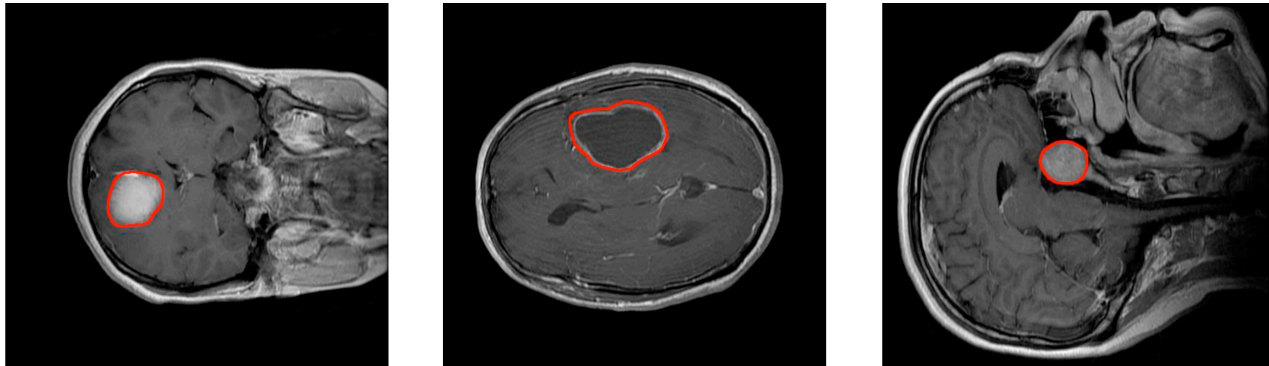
T1-CE MRI image dataset. Left: coronal view of a meningioma tumor. Centre: Axial view of a glioma tumor. Right: sagittal view of a pituitary tumor. Tumor borders have been highlighted in red.
